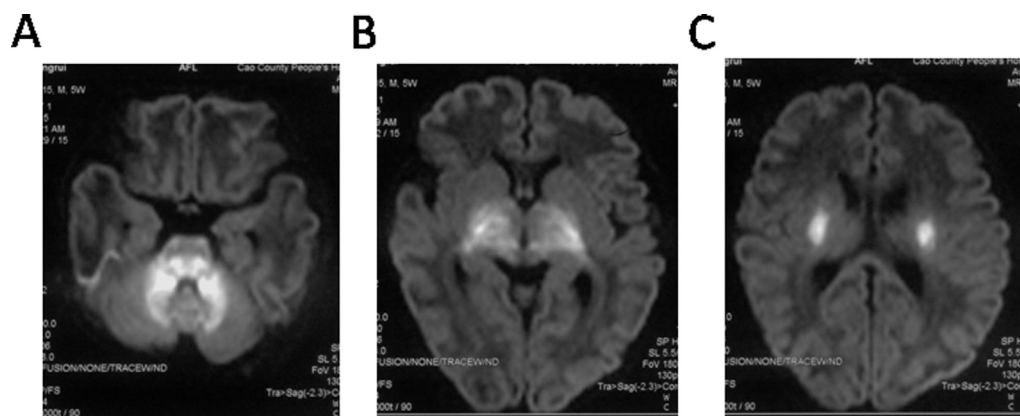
DWI showed hyperintense signal in bilateral dorsal brainstem, white matter of cerebellum (A), thalami, globi pallidi, posterior limbs of internal capsules (B) and corona radiata (C).
